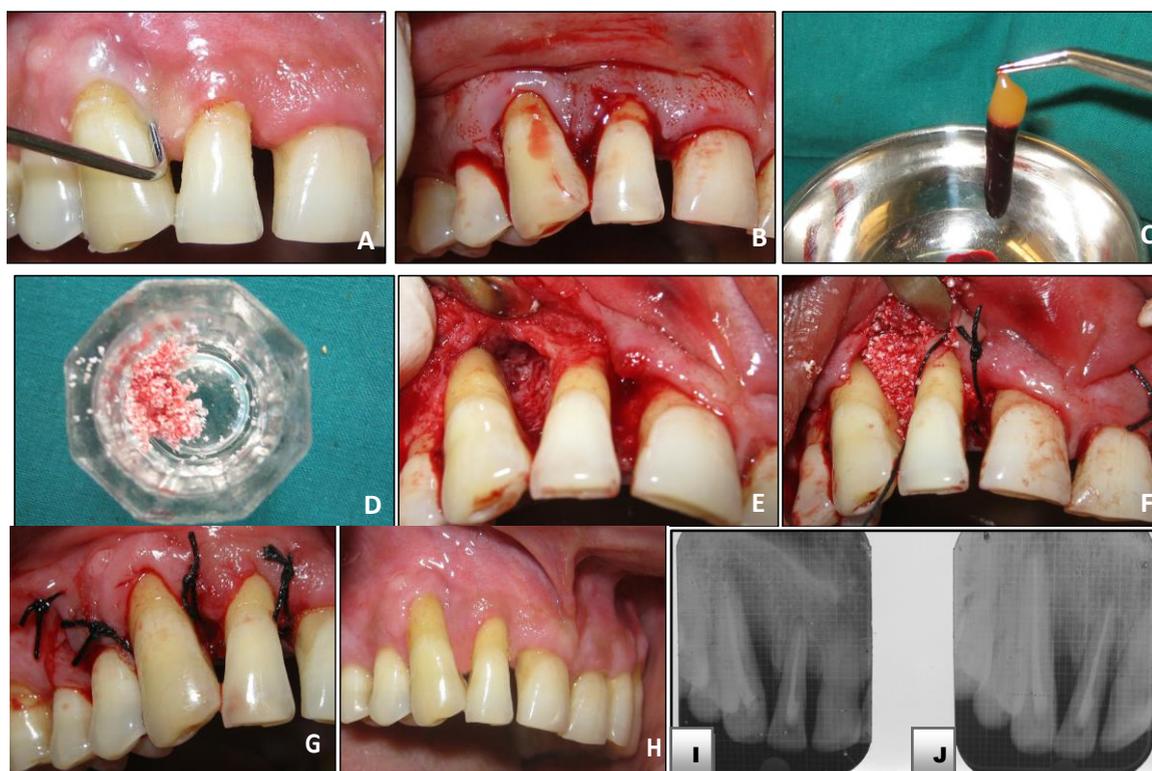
A: Post-operative clinical picture probing Depth: 15mm B: Incision C: Platelet Rich Fibrin D: PRF mixed with bioactive glass bone graft E: Reflection and Debridement F: Graft (Bioactive glass) in place G: Sutures taken H: Post-operative clinical picture I: Pre-operative Radiograph J: Post-operative Radiograph
